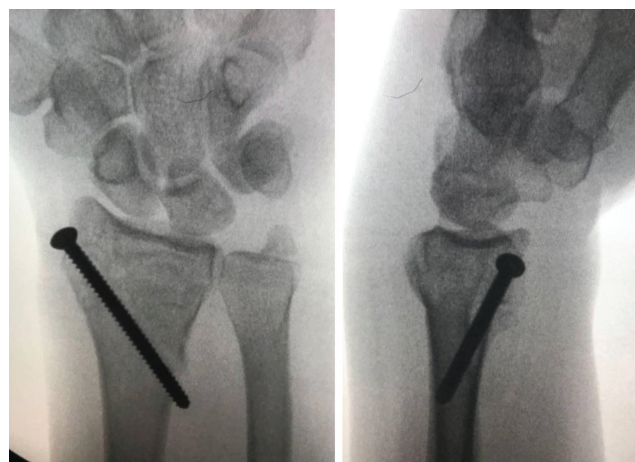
Anteroposterior (AP) and lateral (L) radiographs from an extra-articular fracture of the distal radius.Fig. 2 Incision for percutaneous approach to the fracture.
